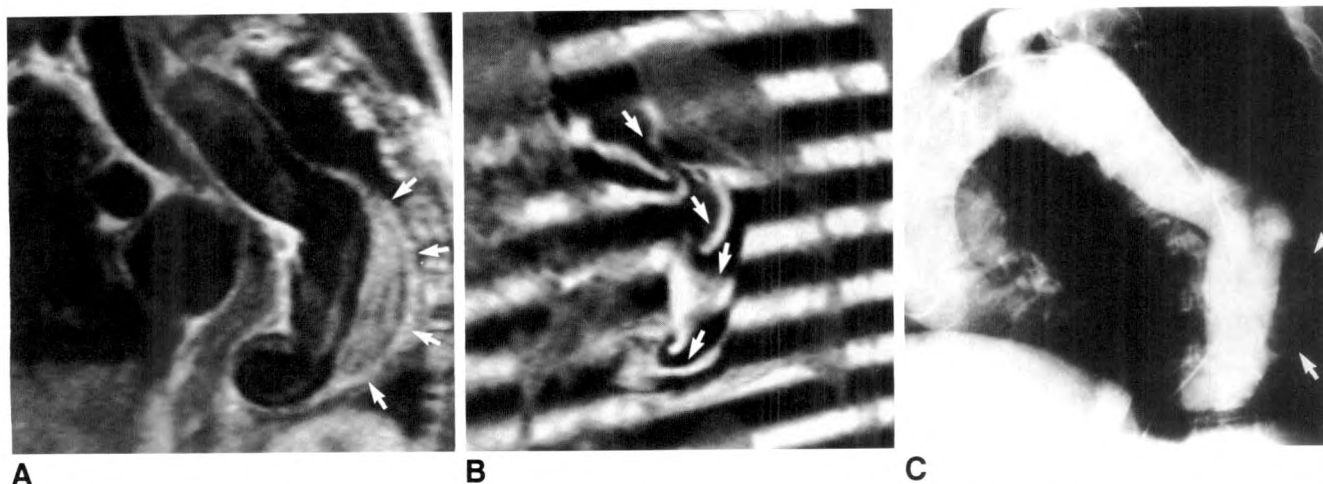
A, MR image in long axis showing detail of descending thoracic aortic aneurysm in systole. Note intraluminal signal throughout aorta, though most intense in periphery of aneurysm (arrows).
